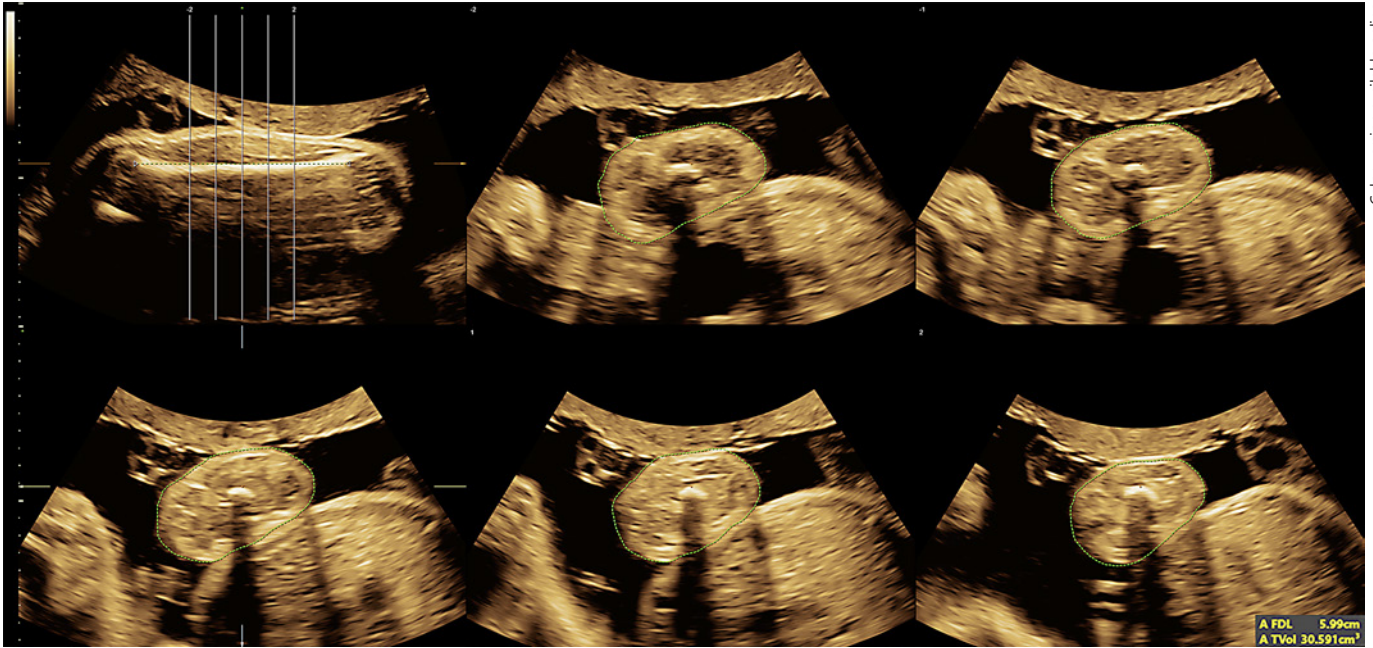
Ultrasound image demonstrating the measurement of fetal thigh volume. The image in the upper left corner is the entire thigh with 5 lines or points of cross-section, where the volumes are measured. The remaining 5 images demonstrate how the volumes are outlined. At the end of the 5th image, the in-built thigh volume software calculates the overall volume.
